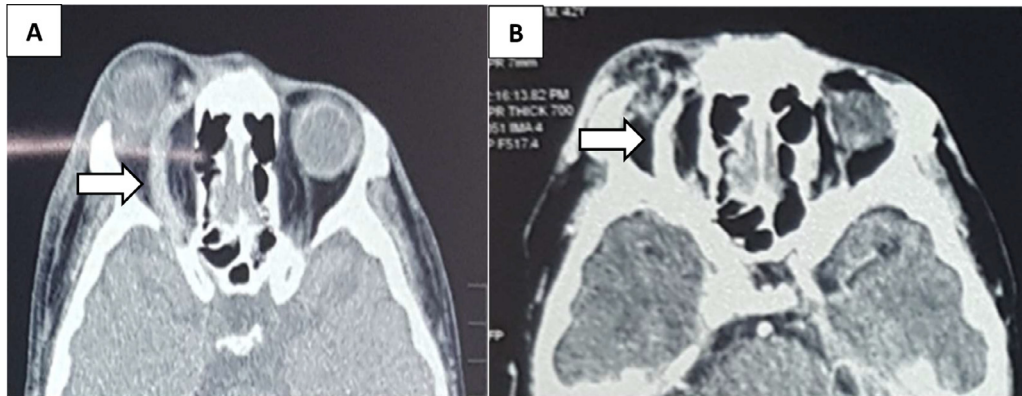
Axial Head CT on April 13th 2021. without contrast (A), Axial Head CT on April 13th 2021 with contrast. (B) showing dilated right superior ophthalmic vein (White arrow).
